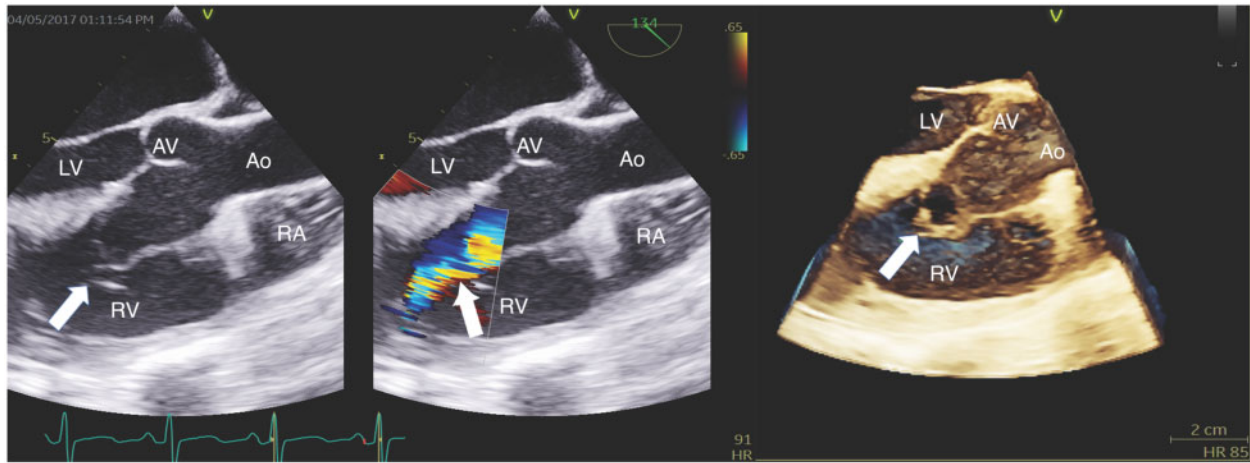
A transoesophageal echocardiography long-axis view (120°) with three-dimensional image showing the ruptured sinus of Valsalva aneurysm with a left-to-right shunt towards the right ventricle. Ao, aorta; AV, aortic valve; LV, left ventricle; RA, right atrium; RV, right ventricle.
